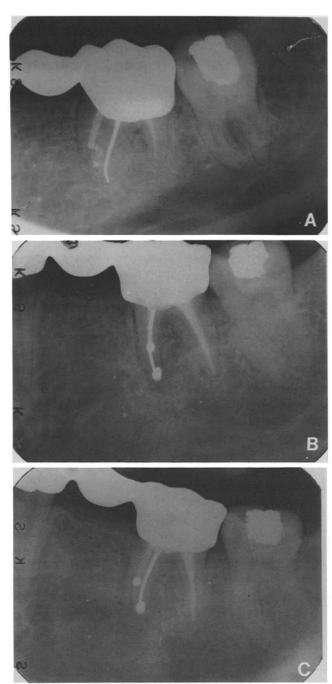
Mandibular first molar. *A*, Preoperative radiograph. Conventional root canal treatment failed and periapical surgery was subsequently performed without retrograde amalgam fillings about 7 months previously. Swelling and constant pain still present. Note the perforation of mesiobuccal canal. *B*, Postoperative radiograph. Mesiobuccal and distal canals were retreated conventionally followed by periapical surgery of the mesial root because the silver point in the mesiolingual canal could not be retrieved with all possible measures. Since the mandibular ridge overlying the roots of first molar was bulky, some of buccal alveolar bone had to be reduced to gain access to the periapical regions. *C*, Follow-up radiograph. One year after periapical surgery, the tooth was asymptomatic. There was evidence of bony healing.
